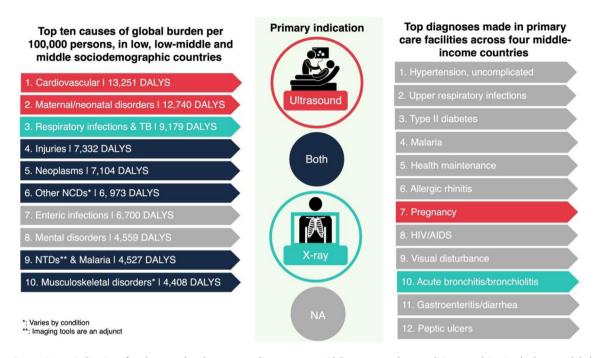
Primary indications for ultrasound and x-ray according to WHO guidelines, mapped to conditions resulting in the largest global burden among low, low-middle, and middle sociodemographic countries and to common diagnoses made in primary care settings across four middle-income countries. DALYs were calculated by summing results from GBD 2019 for low, low-middle, and middle-SDI countries (level 2 causes) obtained from the Institute for Health Metrics and Evaluation's visualization tool: https://vizhub.healthdata.org/. Top diagnoses made in primary care facilities data are derived from Reference.⁸
